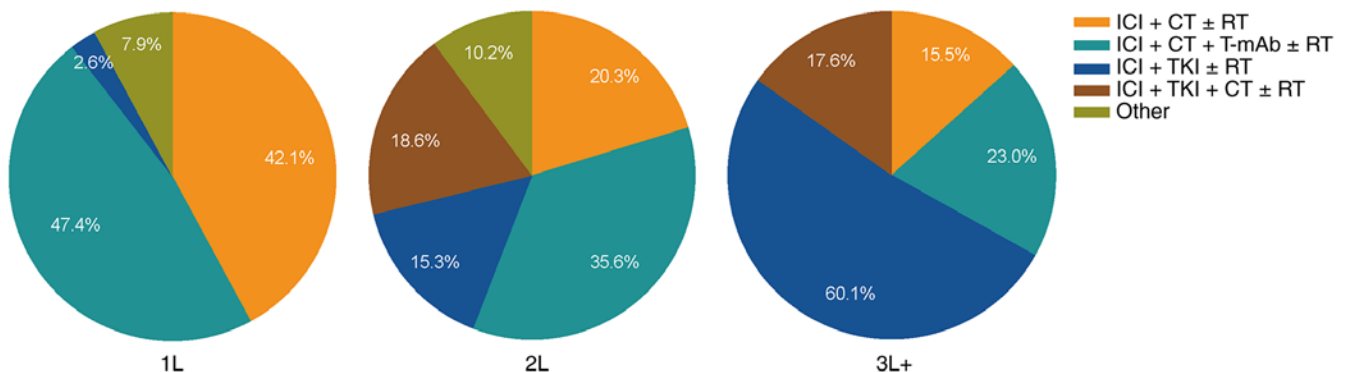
Major treatment regimens and proportions of patients in each cohort. 1L, first-line treatment; 2L, second-line treatment; 3L+, third-line or above treatment; CT, chemotherapy; ICI, immune checkpoint inhibitor; RT, radiotherapy; T-mAb, targeted monoclonal antibody against VEGF(R), EGFR or HER2; TKI, tyrosine kinase inhibitor.
